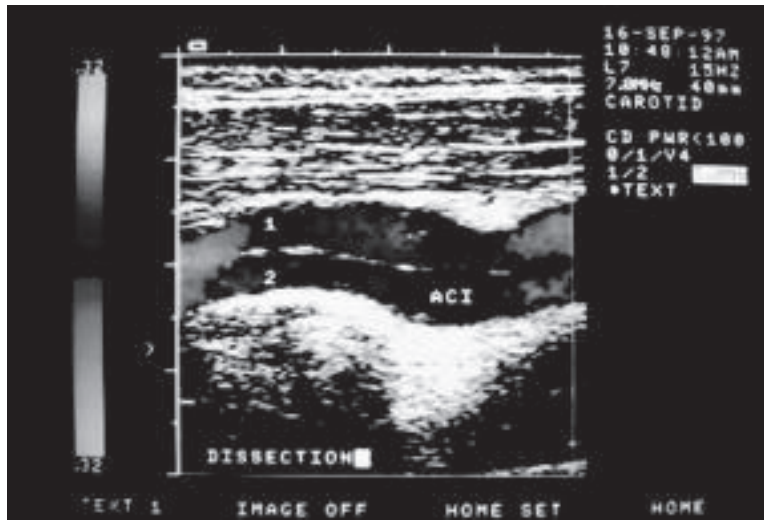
Color Doppler flow imaging of an internal carotid artery dissection
